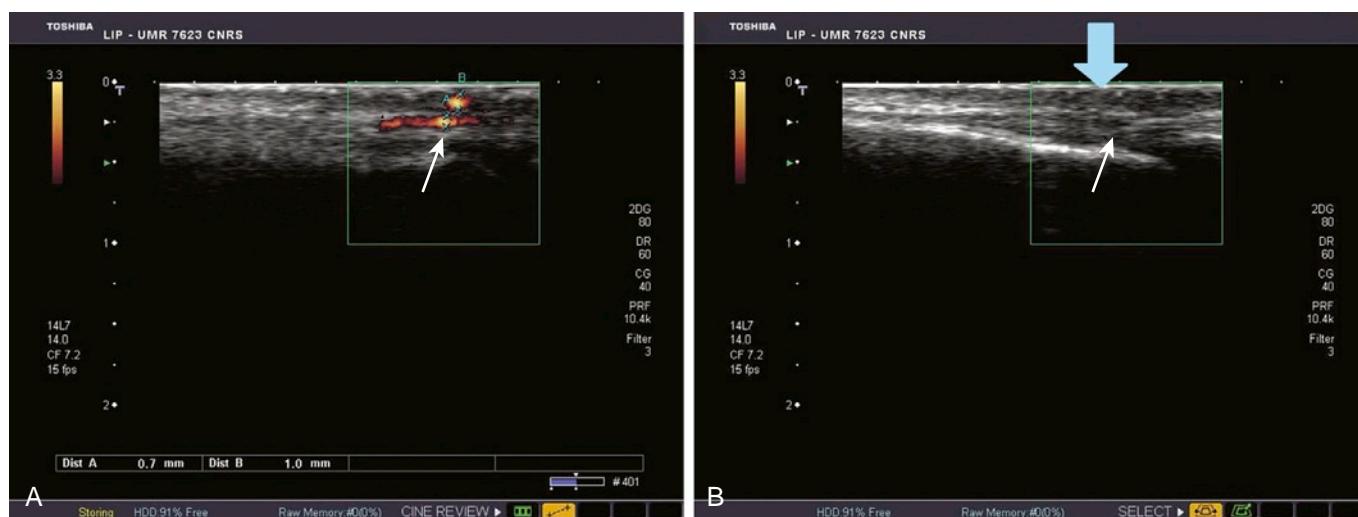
REAL-TIME FLOW MODIFICATIONS. A, The power Doppler image shows flow in a superficial vessel (arrow). To visualize this flow, care must be taken not to press the transducer against the subject. B, The same zone was imaged as the transducer was pressed against the subject (pressure applied indicated by the blue arrow). The arrow marks the position of the vessel. Flow is no longer observed. Flow modifications can be seen in real time. For superficial flow assessment, it is important to avoid interfering with flow by unintentionally applying pressure to the vessels (see the corresponding video on the Expert Consult Web site).
